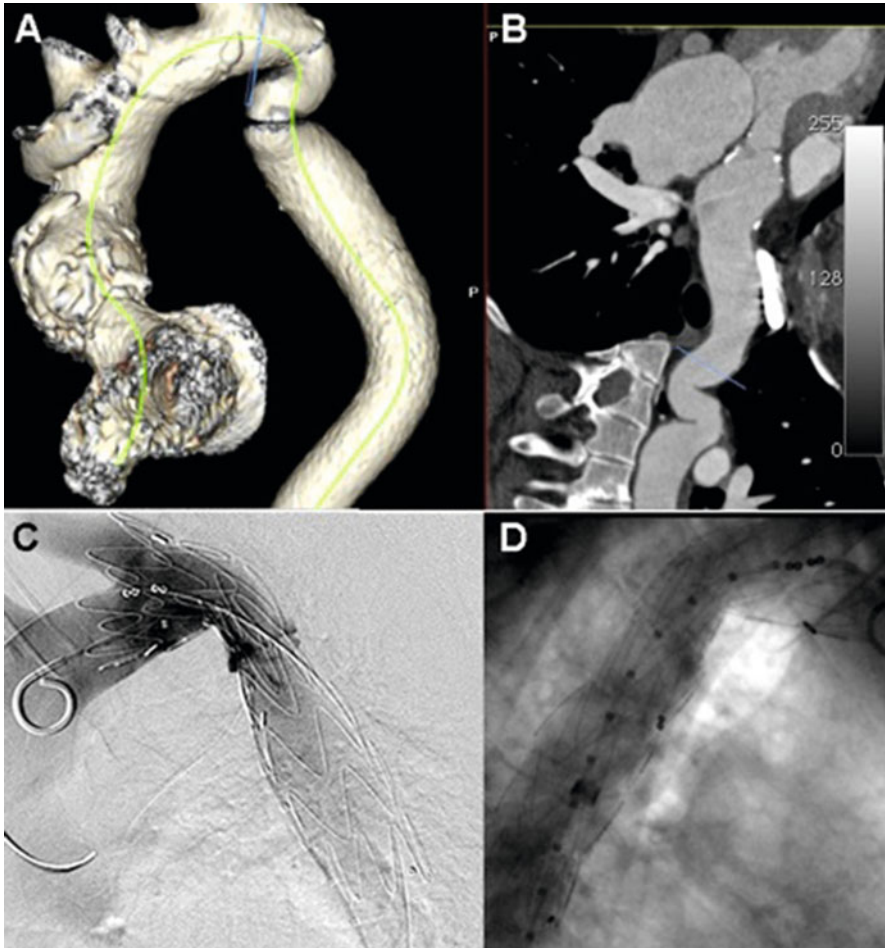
(a) CT angiogram with 3-D volume rendering, left anterior oblique view, demonstrating a complex coarctation with severe tortuosity of the distal aortic arch and proximal descending thoracic aorta. (b) Multi-planar reconstruction of the aorta demonstrating the S-shaped tortuosity with multiple areas of stenosis. (c) Aortic angiogram with digital subtraction, left lateral view demonstrating a covered self-expanding stent graft within the distal arch and descending thoracic aorta with subsequent placement of a high radial force balloon expandable stent within the tortuous portion of the aorta. Note the resolution of aortic tortuosity and stenosis. (d) Aortic angiogram, right anterior oblique view, demonstrating resolution of stenosis and tortuosity
